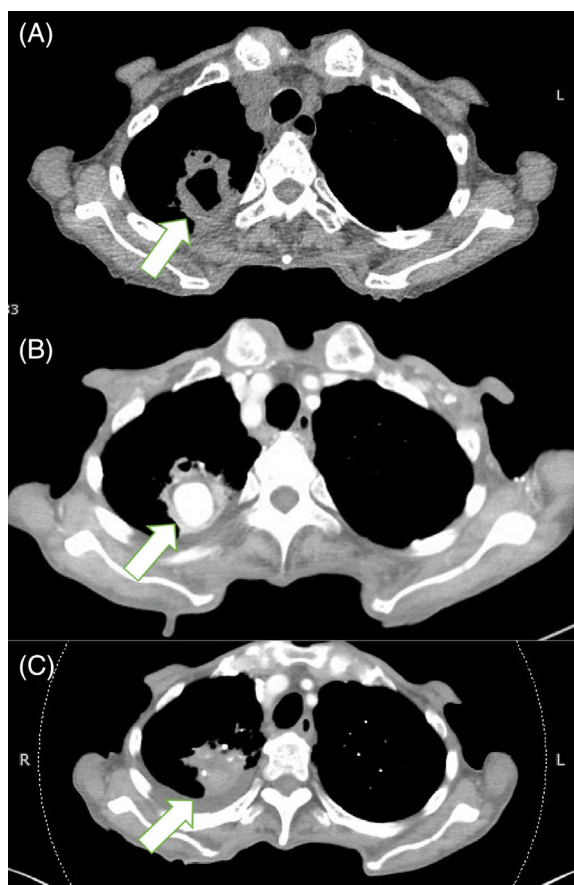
(A) Plain CT at another hospital 6 days before admission showed a large cavitary lesion in the right upper lobe (arrow), (B) Contrast-enhanced CT on admission showed pulmonary pseudoaneurysm (arrow), and (C) Contrast-enhanced CT after coil embolization showed no blood flow in the aneurysm (arrow)
